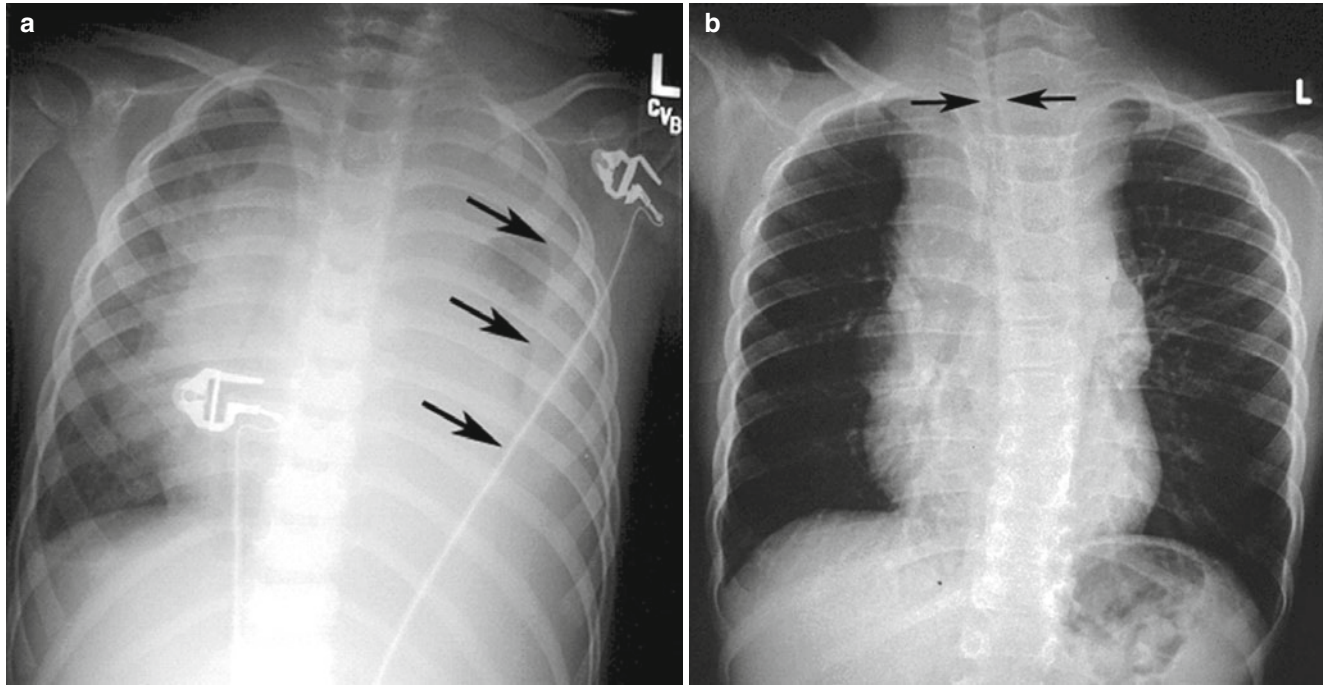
Chest radiographs demonstrating pleural effusion (a, arrows demonstrate the edge of a large pleural effusion) and tracheal compression (b, arrows demonstrate narrowing of the trachea secondary to a mediastinal mass) associated with a mediastinal mass
